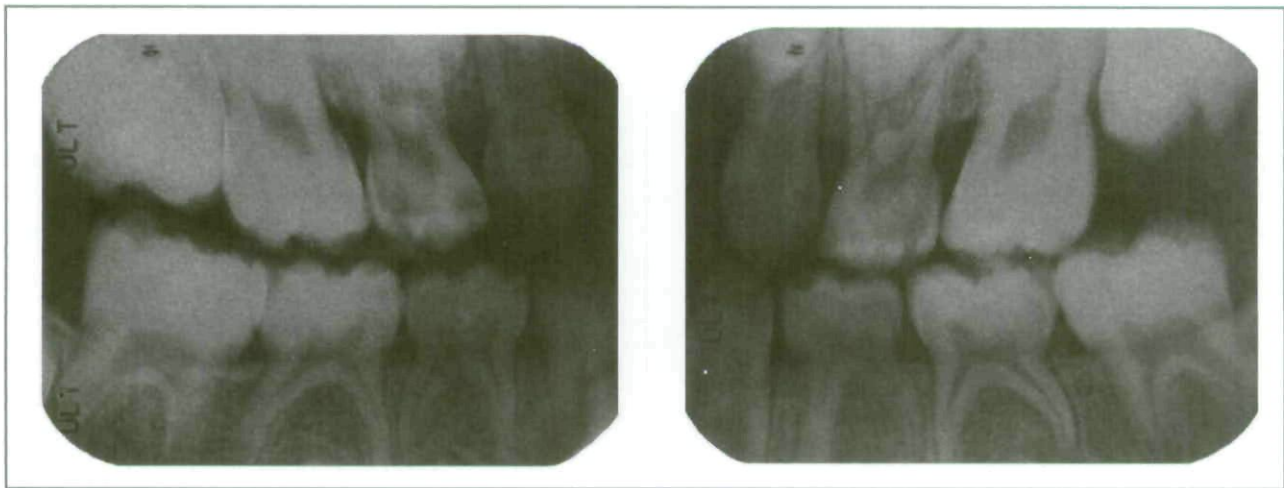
Pretreatment bitewing radiographs of a 7-year-old patient with sideroblastic anemia.
